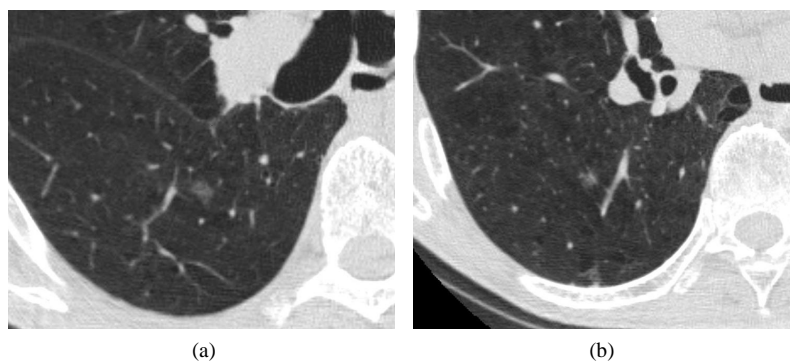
Chest CT in November 2008 showing two localized GGOs measuring 7 mm (a), and 6 mm (b) in diameter in S6 of the right lower lobe.
